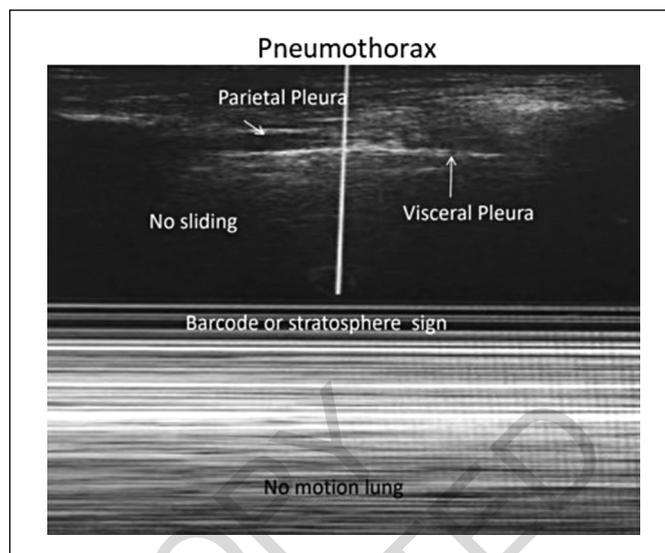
CUS signs of PTX. Lung sliding is absent, the pleural line is static during respiration. Parallel lines that look like waves in M-mode (Barcode or stratosphere sign). CUS: chest ultrasound; PTX: pneumothorax.
